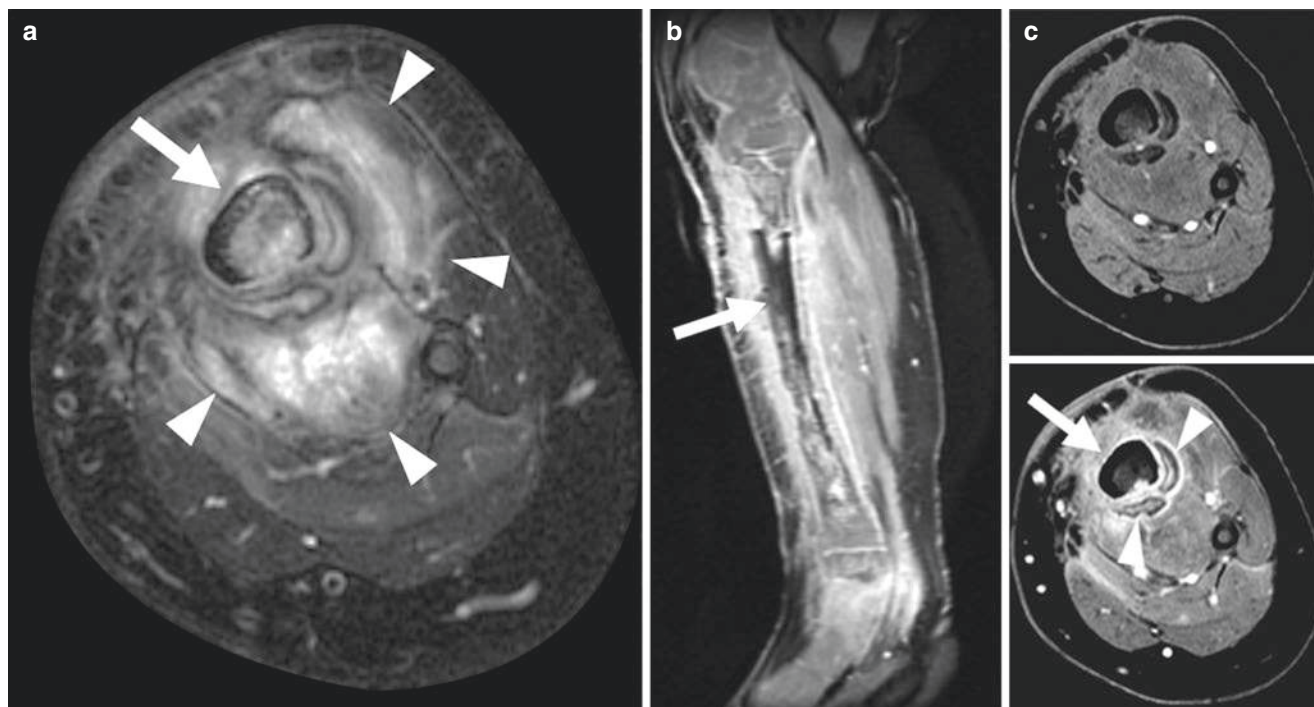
10-year-old boy with chronic leg pain, fevers. Biopsy-proven osteomyelitis. Axial T2-weighted fat suppressed image (a) of the lower leg demonstrates abnormal signal in the tibia (arrow) representing osteomyelitis. Note surrounding phlegmonous tissue (arrowheads). Sagittal T1-weighted fat suppressed post contrast image (b) and axial
